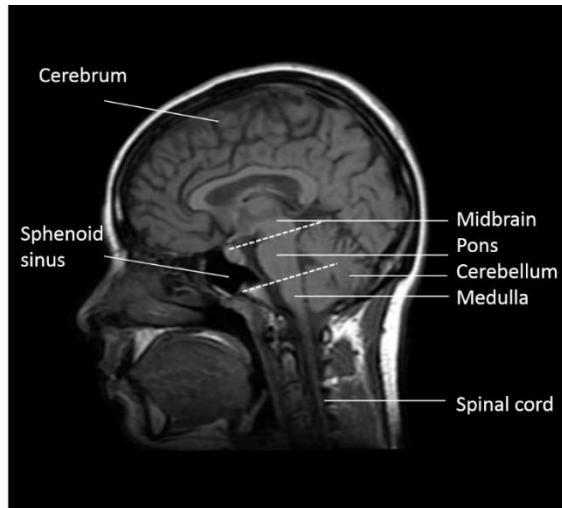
T1 weighted MRI of the brain (sagittal slice). The brainstem connects the cerebrum with the cerebellum and the spinal cord. It consists of three segments: the medulla oblongata (medulla), pons, and metencephalon (midbrain). Note that the brainstem is located closely to the sphenoid sinus.
